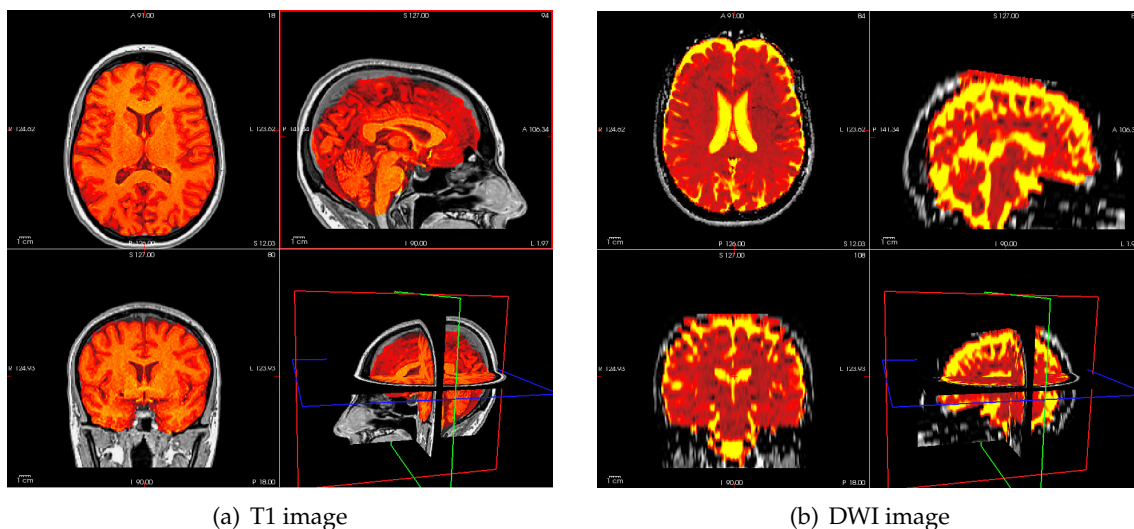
The original image of an example dataset (grey scale) and the result of the BET (heat colormap) for a T1 image (a) and a DWI image (b).
